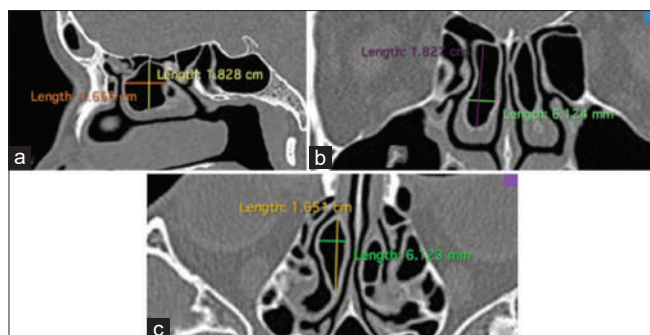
Right side volume measurement on sagittal (a), coronal (b) and axial (c) CT images of patients with bilateral pneumatized middle turbinate, CT: Computed tomography
